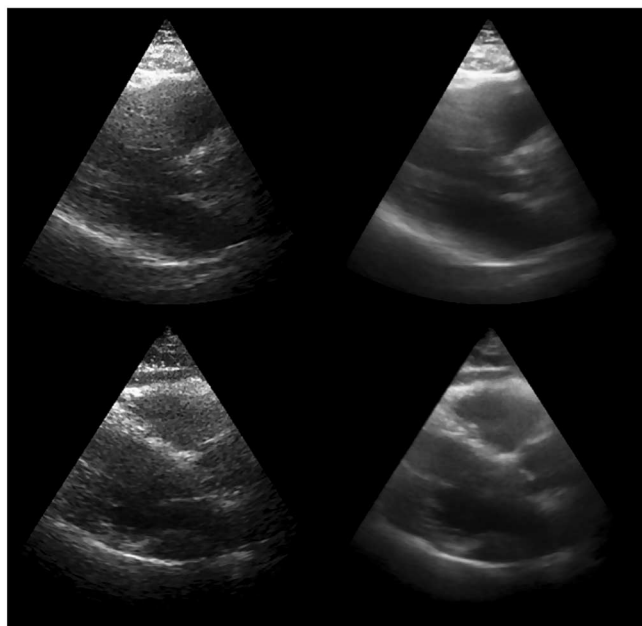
Original (left) and compound (right) parasternal long axis ED frames of low image quality and diagnostic value. The images are generated using the temporal compounding approach as described in [105] and [112]. Compounding suppresses tissue speckle and chamber noise substantially. Data remain of low diagnostic value but some structures such as the IVS and RV (top), and the IVS, RV, LVPW, and aortic valve (bottom) marginally enhanced enabling their delineation. The figure has been reproduced with relevant permission from [112].
